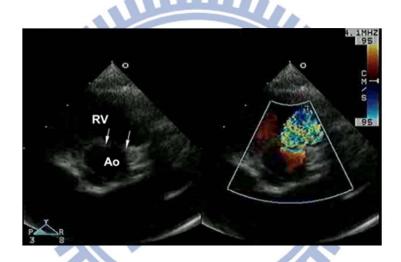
Echocardiography discerns normal and a patient of VSD. (A) A normal child; (B) A patient of medium size of perimembranous VSD. The white arrows indicate the site of VSD. LA, left atrium; LV, left ventricle; RV, right ventricle; Ao, aortic valve.
